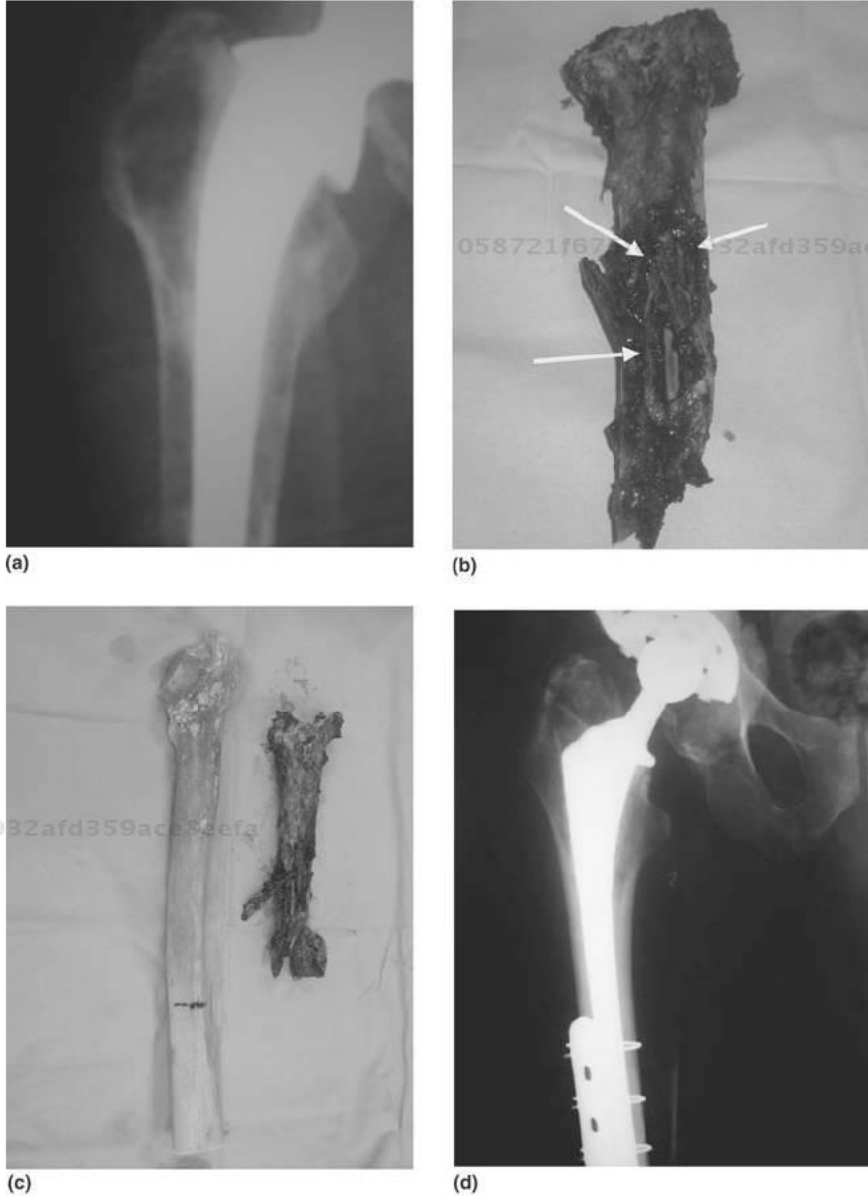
X-rays and photographs showing fracture and treatment. (a) X-ray of hip arthroplasty. (b) Resection of a proximal femur showing several metallosis areas. (c) Massive proximal femur replacement allograft. (d) Postsurgical radiography with a wired plate to reinforce the union between the proximal femur allograft and the patient's femur. Courtesy of Carlos Cuervo-Lozano, M.D., and José Fernando de la Garza-Salazar, M.D.
